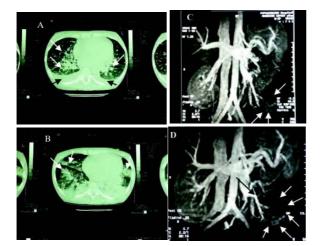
A. High resolution computed tomography (HRCT) of the thorax revealed multiple peribronchial hemorrhagic infiltrates (ground glass opacification) and unilateral pleuritic effusions. B. HRCT during alveolar hemorrhage relapse when the patient was hospitalized in the ICU. C, D. Magnetic resonance imaging (MRI) angiography of the kidneys revealed left renal vein thrombosis and ischaemia of the lower part of the left kidney in the toxoid arteries region.
